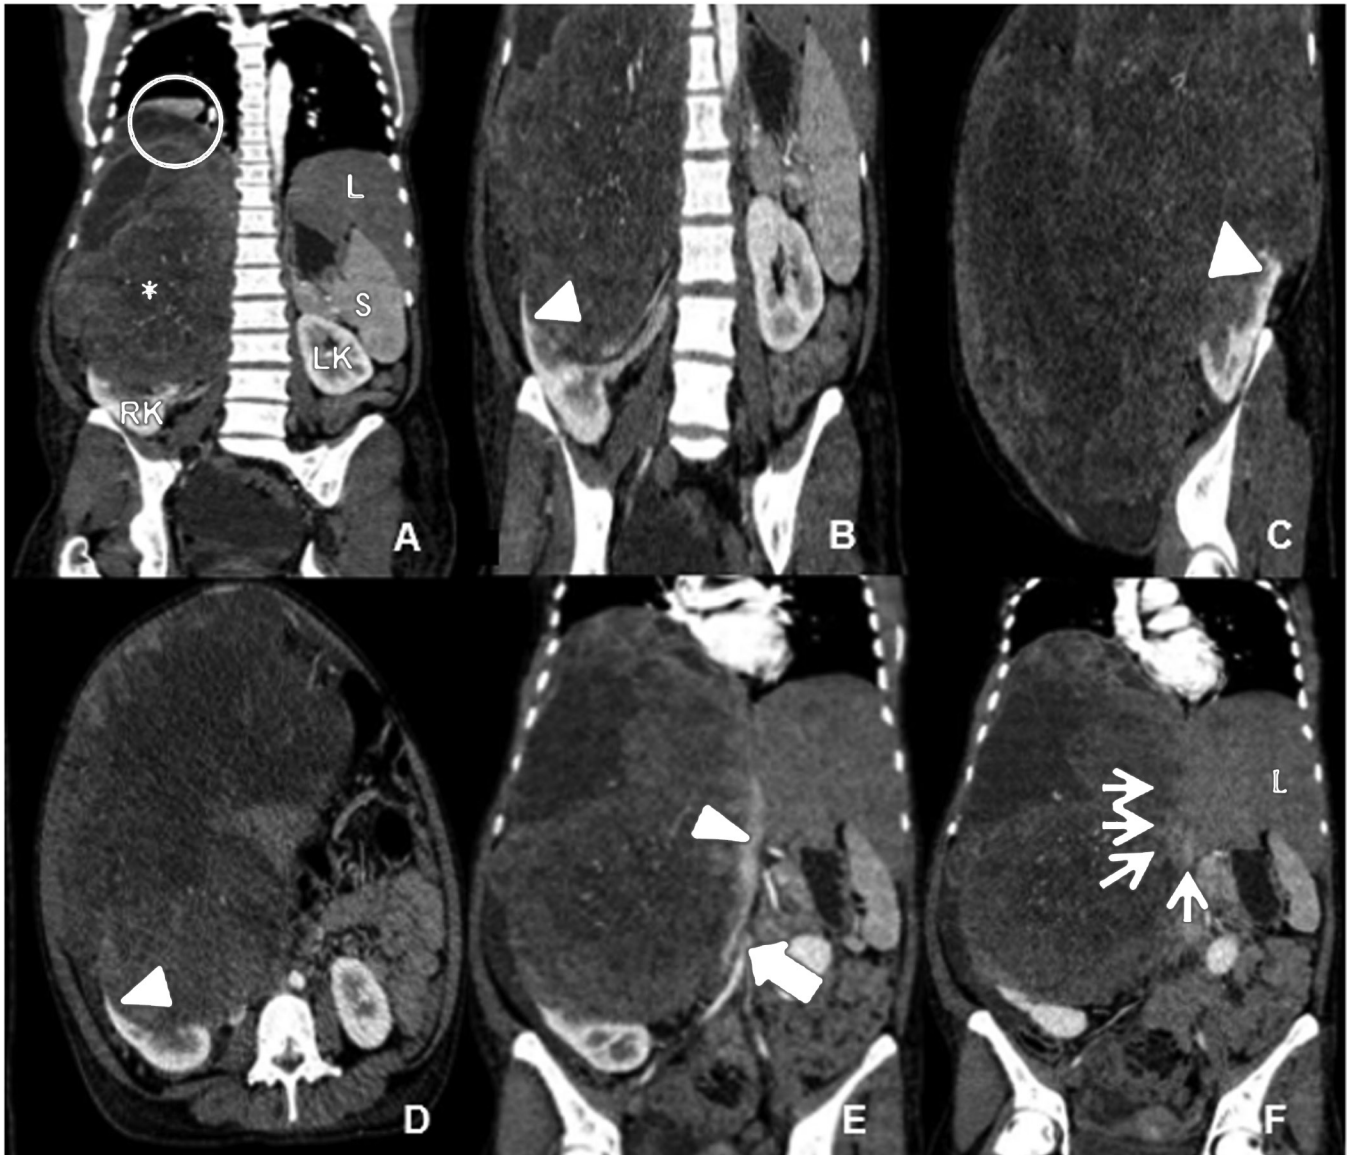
CT of the abdomen with contrast. A) CT scan with contrast revealed a mass 30cm x 19cm heterogeneously enhancing mass (*) arising from the superior and middle pole of the inferiorly displaced right kidney (RK). Note a suspicious infiltration into the right hemidiaphragm (encircled) with the liver shifted to the left hemiabdomen (L) thereby relocating the spleen (S) below it. The left kidney (LK) also appears to be shifted inferiorly, noted between L2 and L4. B) Radiographic findings suggesting that the mass originated from the kidney (arrow heads). C) Sagittal section showing the inferior vena cava (arrow head) and abdominal aorta (arrow) has been displaced to the left hemiabdomen. Also note that the vena cava is compressed. D) Sagittal section shows no definite distinction between the mass and the right lobe of the liver (L).
